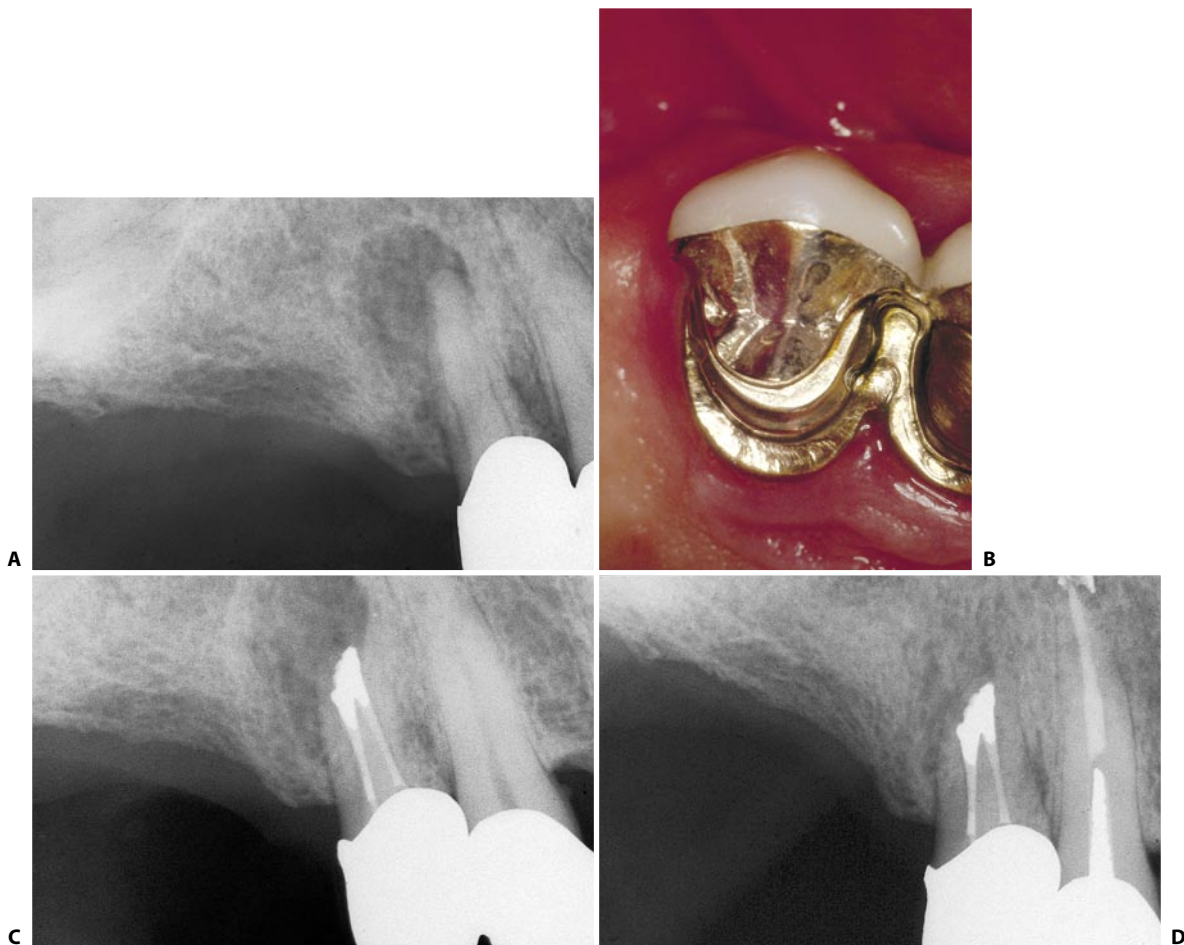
Retrograde endodontic therapy performed because it was not possible to perform a proper access cavity. A. Preoperative radiograph of an upper right first premolar with necrotic pulp and a periapical lesion. B. Occlusal view of the prosthetic crown of the premolar on which the removable prosthesis is inserted. So as not to destroy the complex intracoronal attachment and then so as not to have to revise the prosthesis, a surgical approach was chosen. C. Postoperative radiograph. The canals have been cleaned and shaped, first by hand, then by ultrasonic files, after which they were obturated with a small amount of sealer and thermoplastic gutta-percha. D. Recall radiograph three years later.
